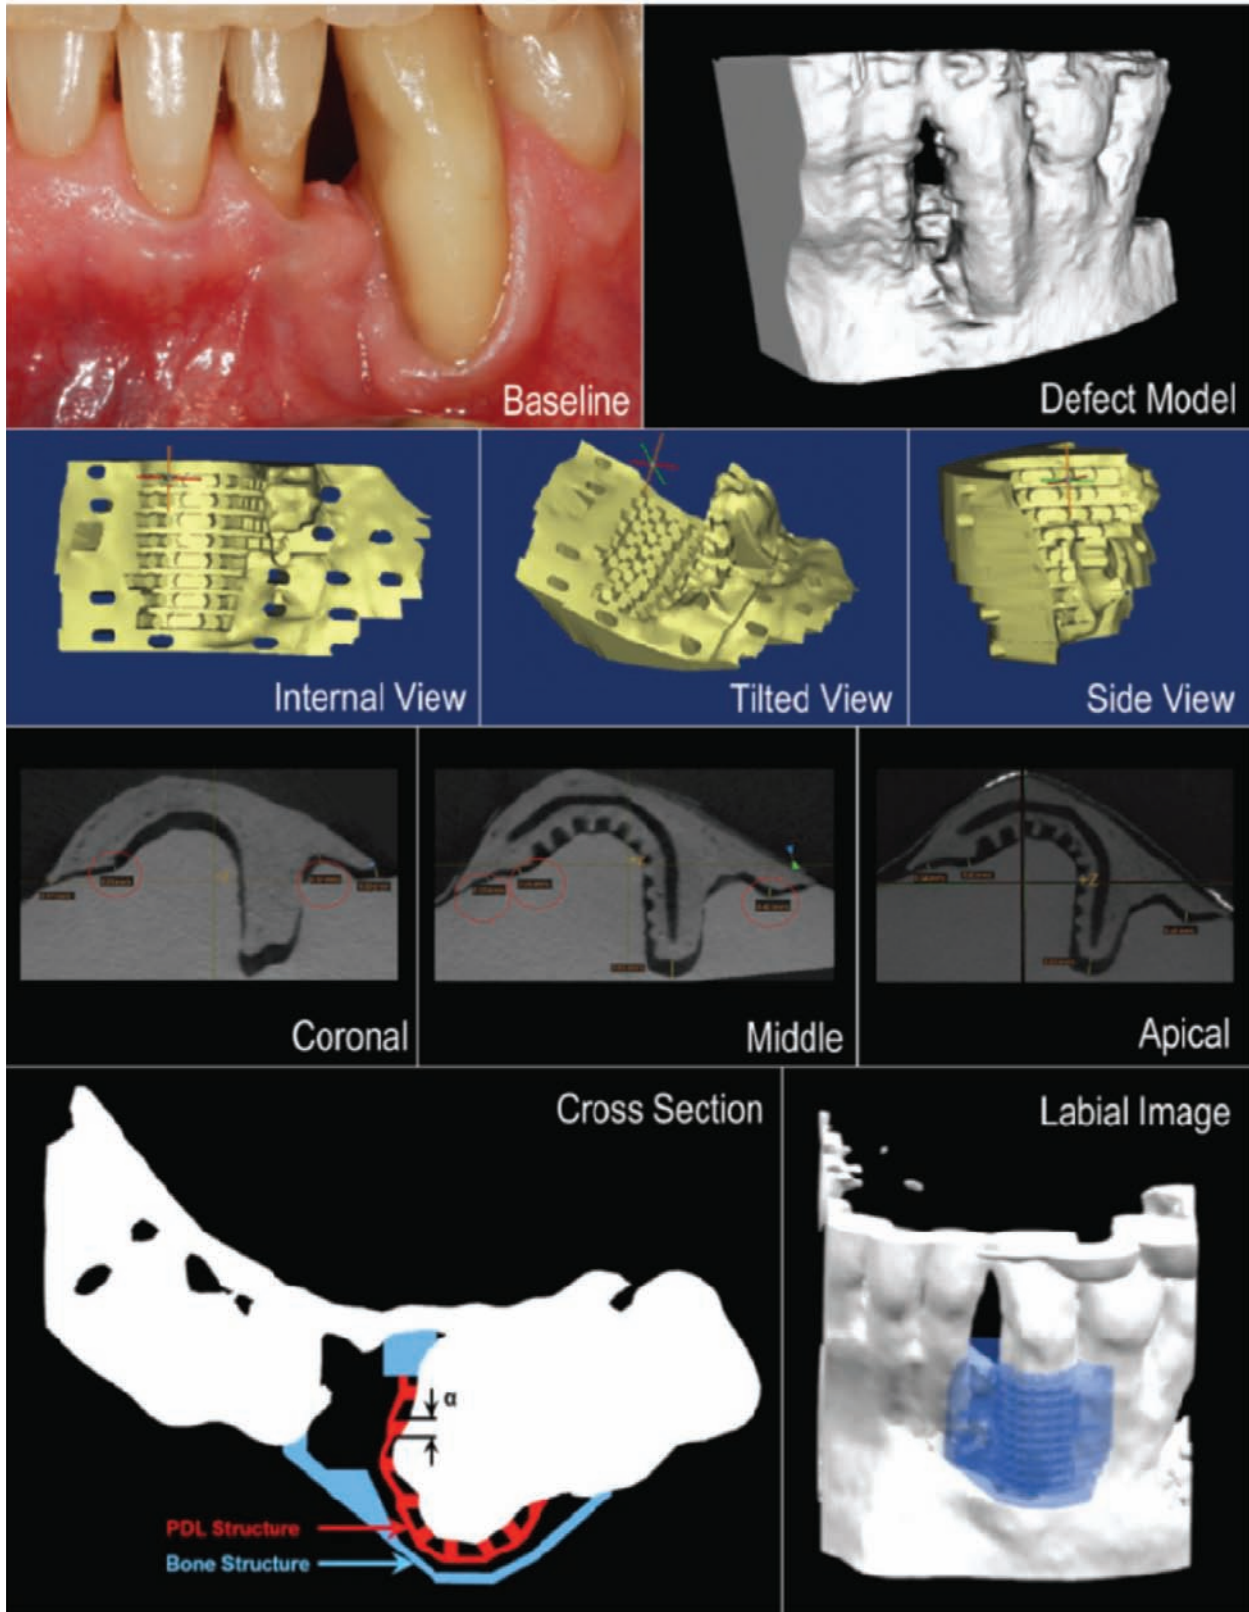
Customized scaffold was 3D printed using medical-grade polycaprolactone to fit the periodontal defect using a prototyped model of the defect from the patient's cone beam computed tomography scan. Courtesy of Rasperini et al, 2015.
